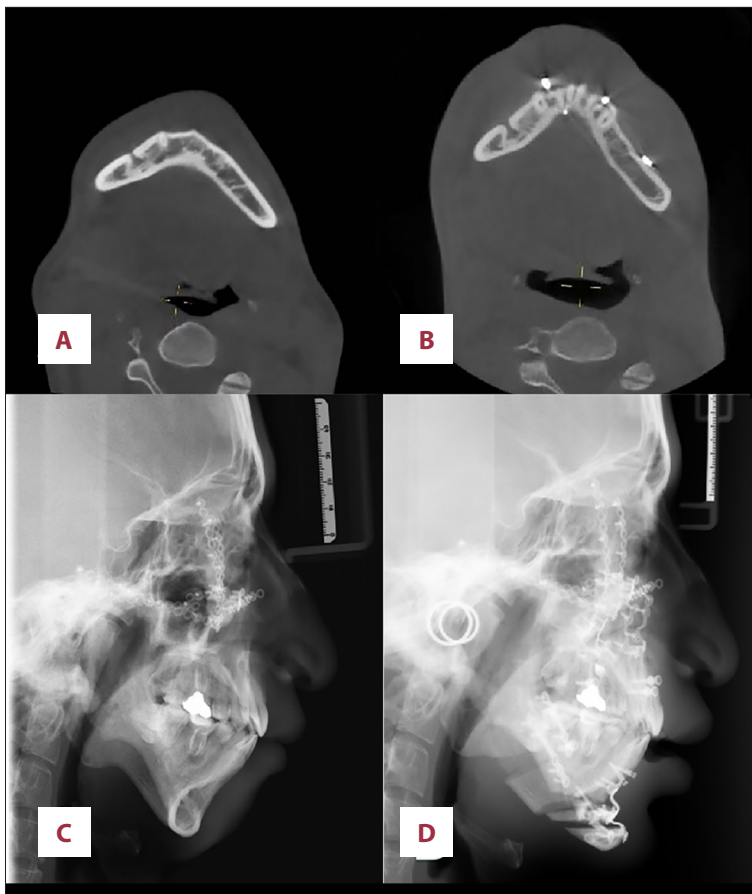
Imaging comparison of skeletal and airway changes after orthognathic surgery. (A, B) Preoperative and postoperative axial cone beam computed tomography images demonstrating the minimum airway width. (C, D) Preoperative and postoperative lateral cephalograms.
